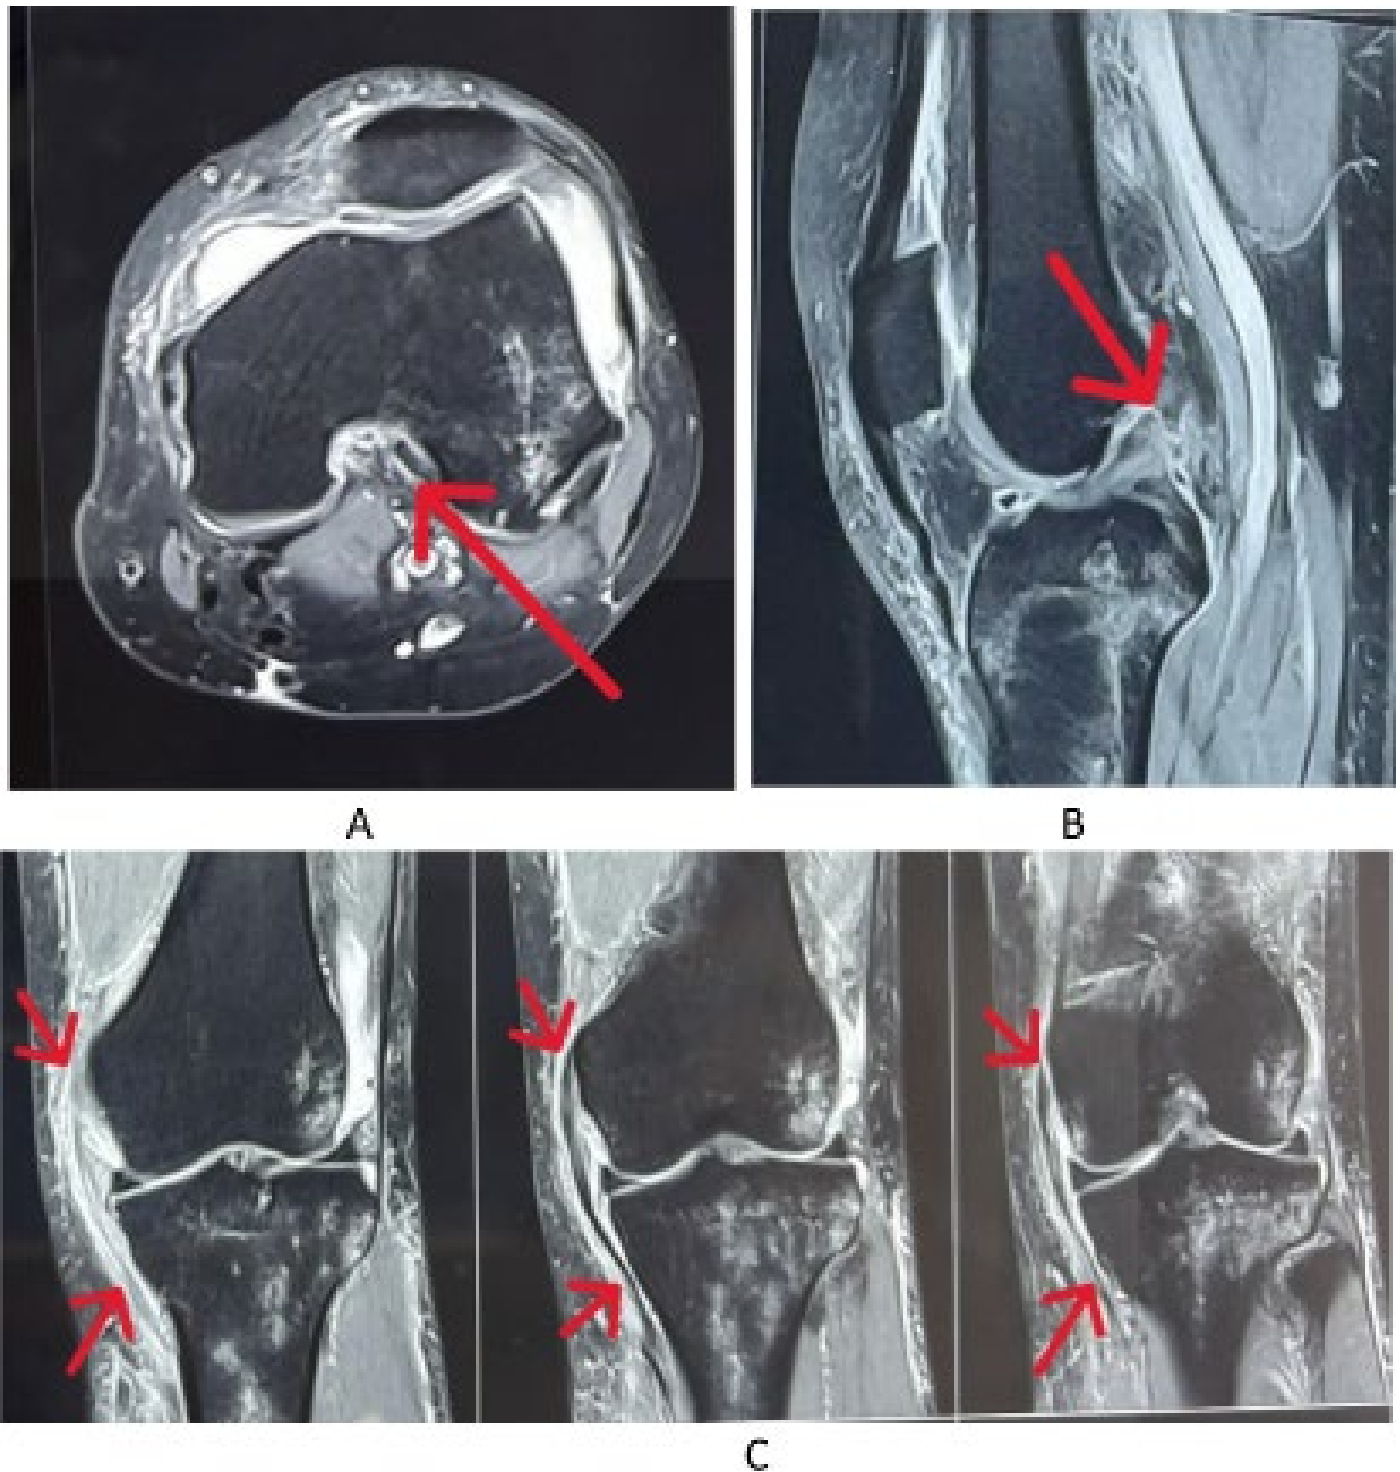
Preoperative MRI findings (STIR sequences). (A) Axial section demonstrating femoral-sided ACL avulsion (arrow). (B) Sagittal section showing avulsed ACL fibers (arrowhead) adjacent to trochlear region. (C) Serial coronal sections revealing: complete grade III MCL tear (arrow), peri ligamentous edema (arrow), and medial compartment gapping indicating laxity.
